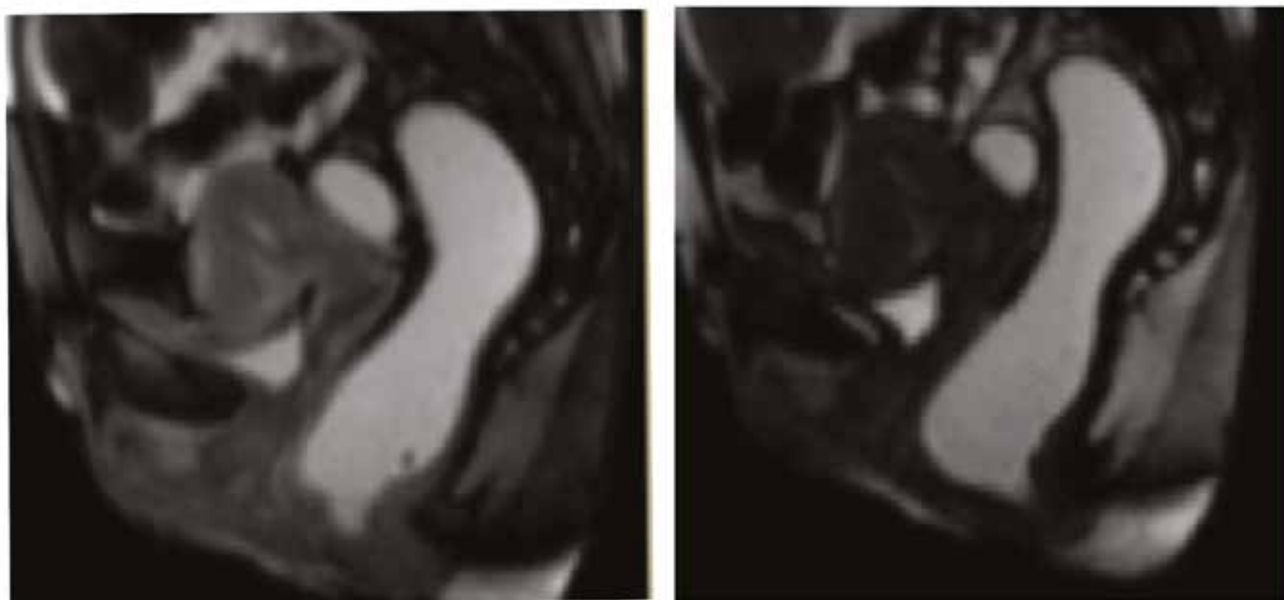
Dynamic pelvic magnetic resonance imaging performed five weeks after the second Botulinum Toxin type-A injection. Anorectal angulation at the relaxing position of 108° (left) and during puborectalis voluntary contraction of 102° (right).
